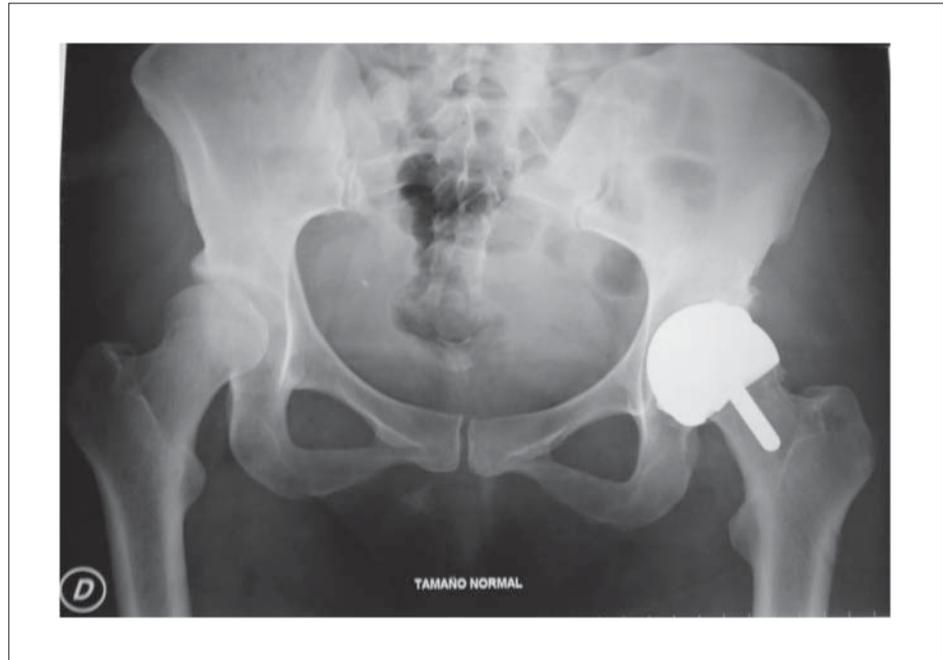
AP pelvis X-ray showing left femoral neck fracture, occurred 4 years after hip resurfacing arthroplasty
